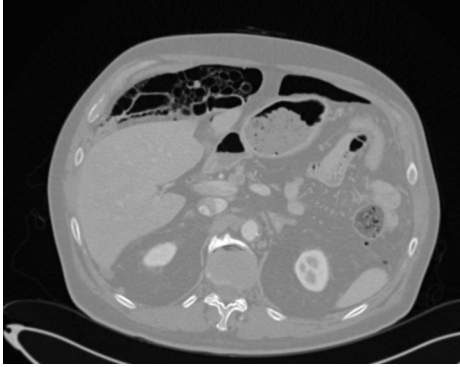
Computed tomography (CT) showed pneumatosis cystoides intestinalis in front of the liver and pneumoperitoneum.
